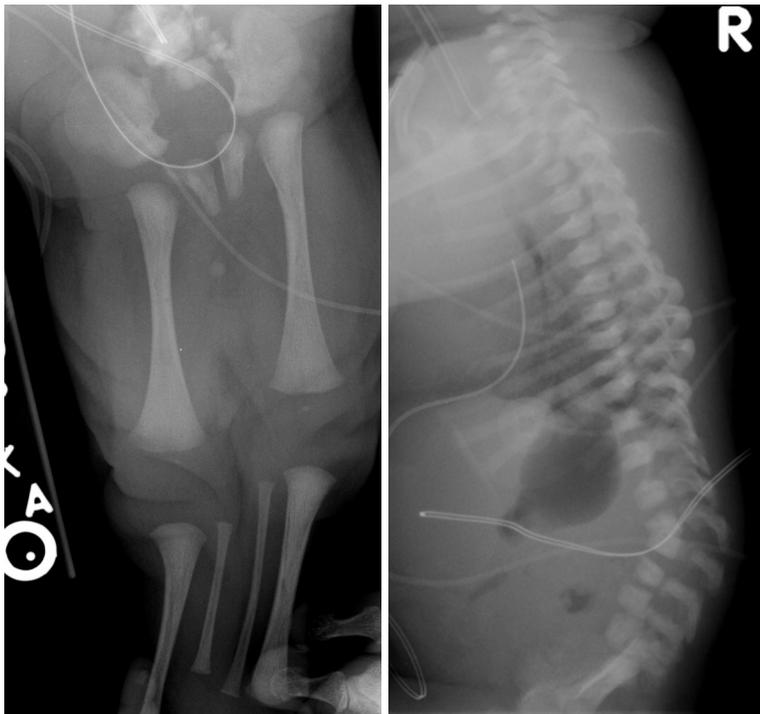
Infant female with sirenomelia. Postpartum radiographs redemonstrate the spinal and extremity deformities.
